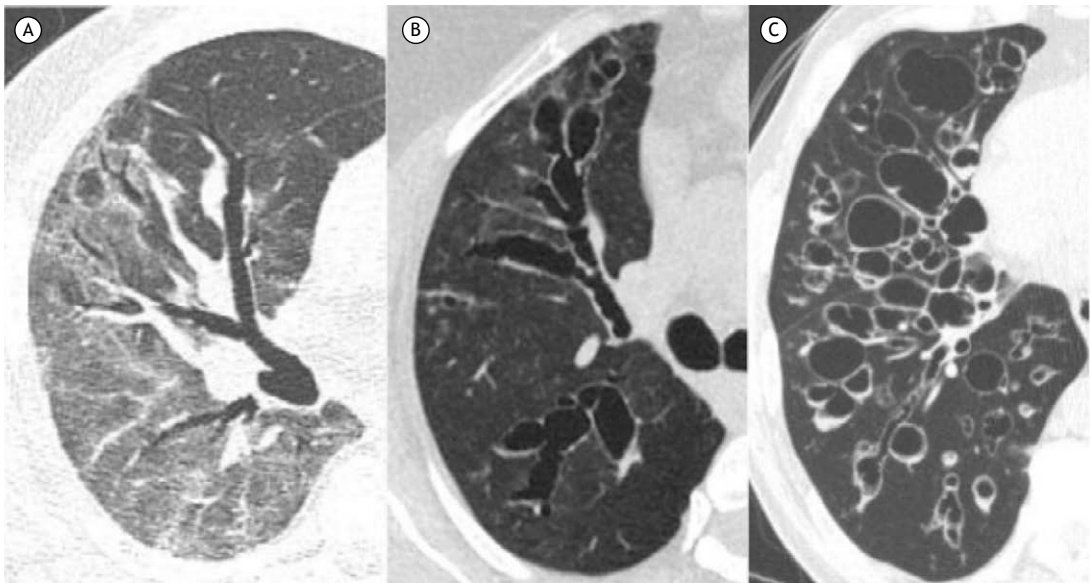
Axial CT scans with lung window settings showing cylindrical (A), varicose (B), and cystic (C) bronchiectasis.
